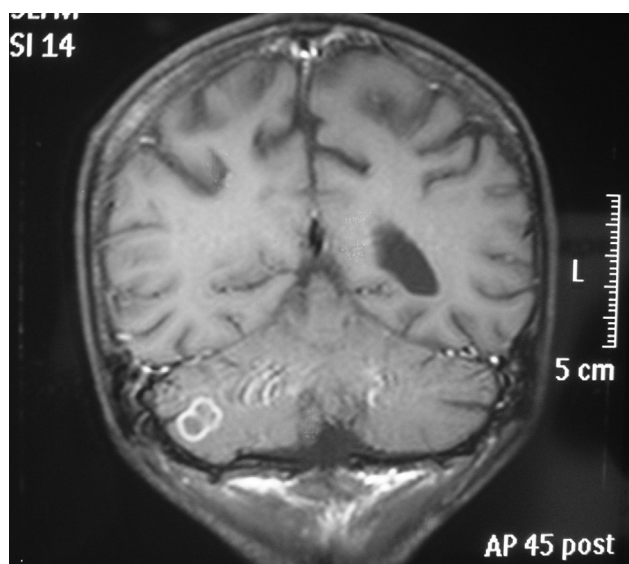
Lesion on the right cerebellar hemisphere of approximately 1 cm, which was hypointense in T1 and hyperintense in T2 weighted images in cranial MRI.
